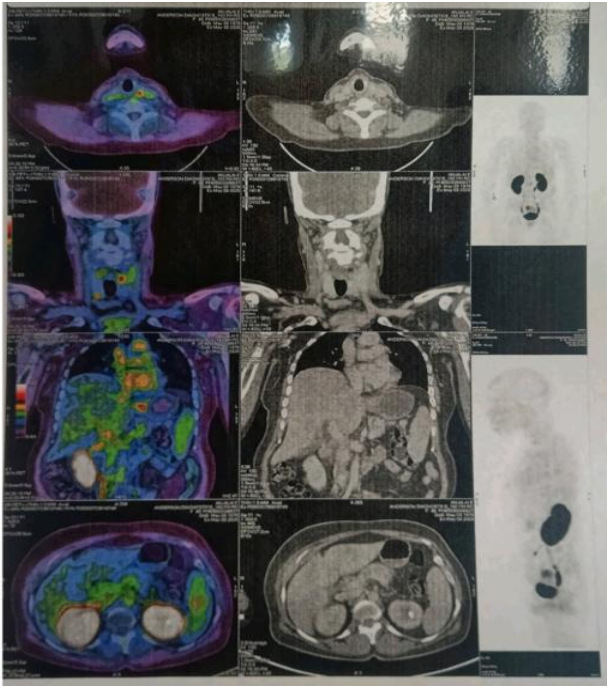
68Ga-Trivehexin whole-body PET/CT scan.
